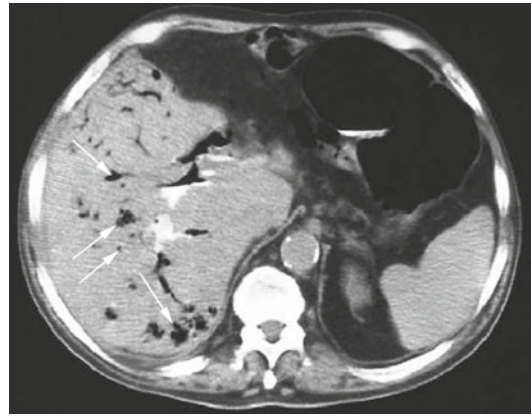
CT shows some air content within the hepatic parenchyma
